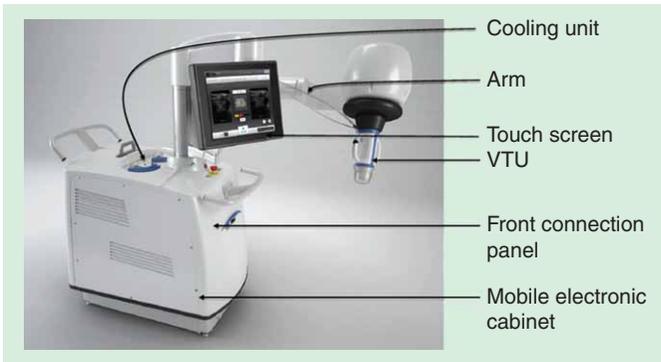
Ultrasound-guided focused ultrasound ablation device (Echopulse, Theraclion).
